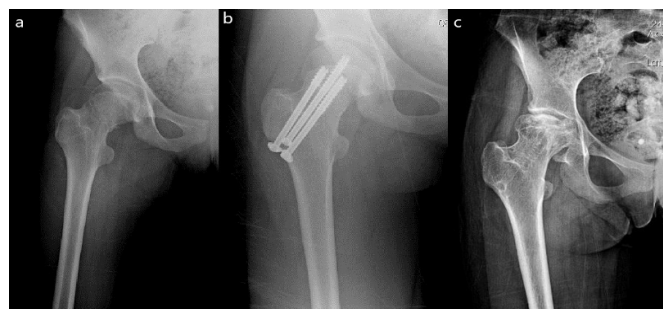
Preoperative (a), early postoperative (b) and postoperative first-year (c) radiography of the patient who developed avascular necrosis.
